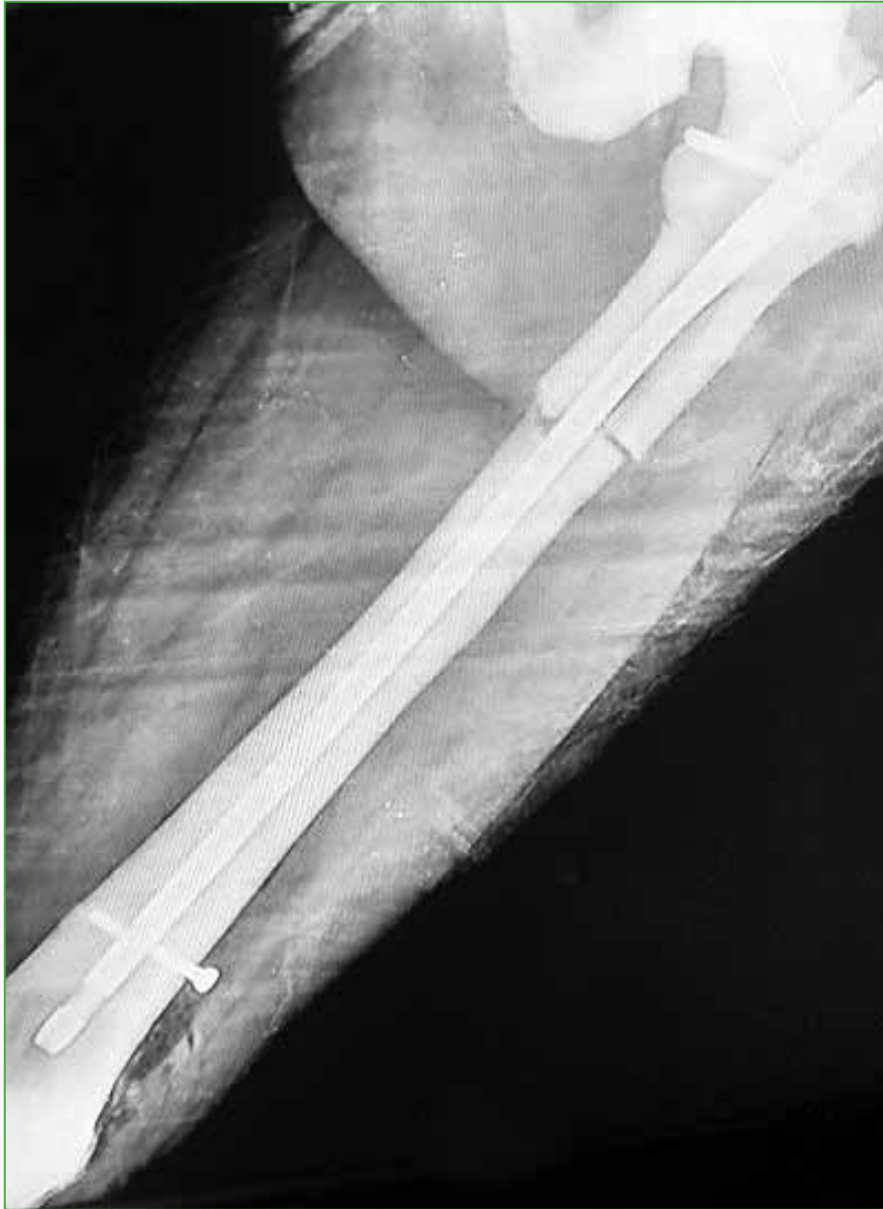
Postoperative control radiograph of osteosynthesis of the proximal femur with a long locking intramedullary nail.
